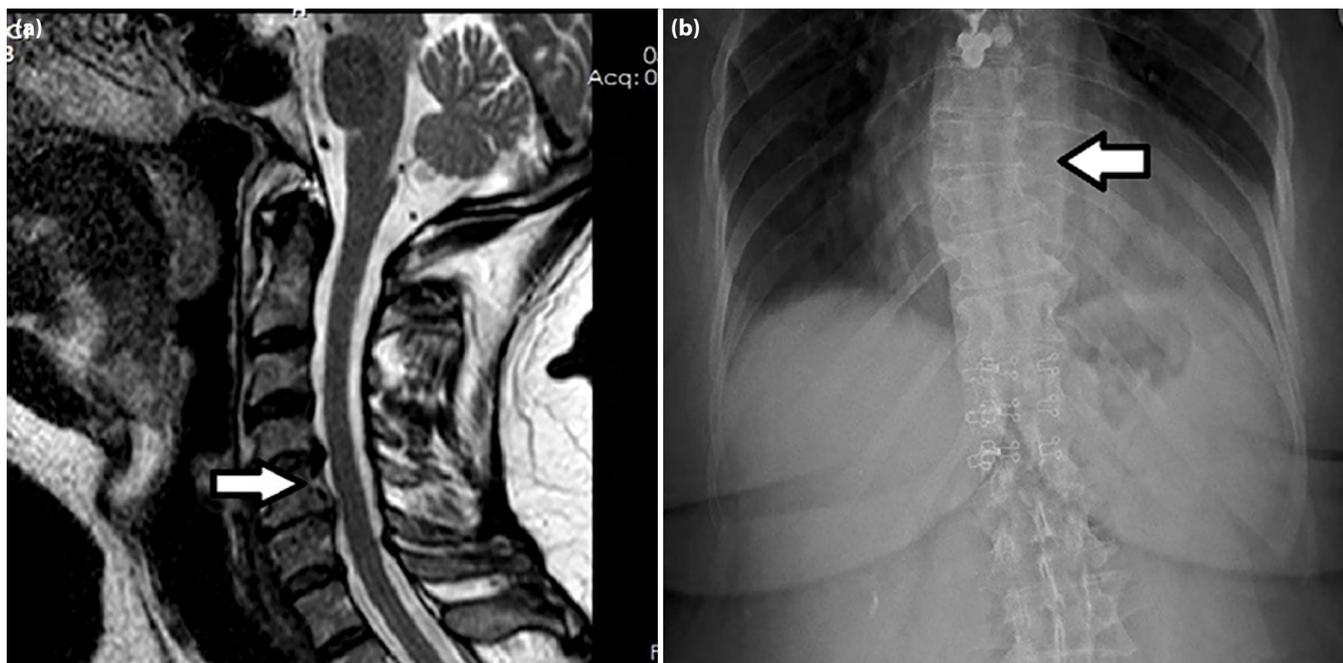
(a) T1 weighted sagittal dorsal spine MRI image demonstrated with arthropathy C4-C5. (b) Thoracic hernia and mild scoliosis on x-ray imaging.
